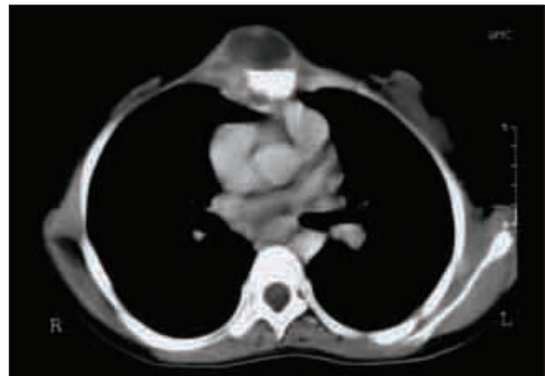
Computed tomography of the thorax.
